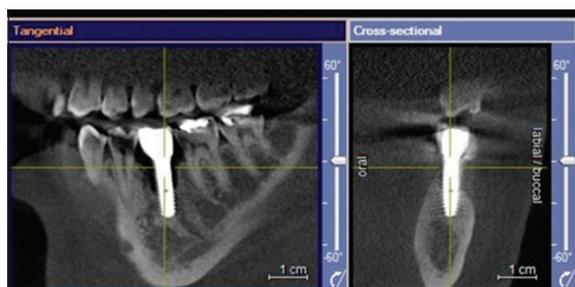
Cone-beam computerized tomography of implant placed in 36. (Courtesy: Omar Mohamed)
